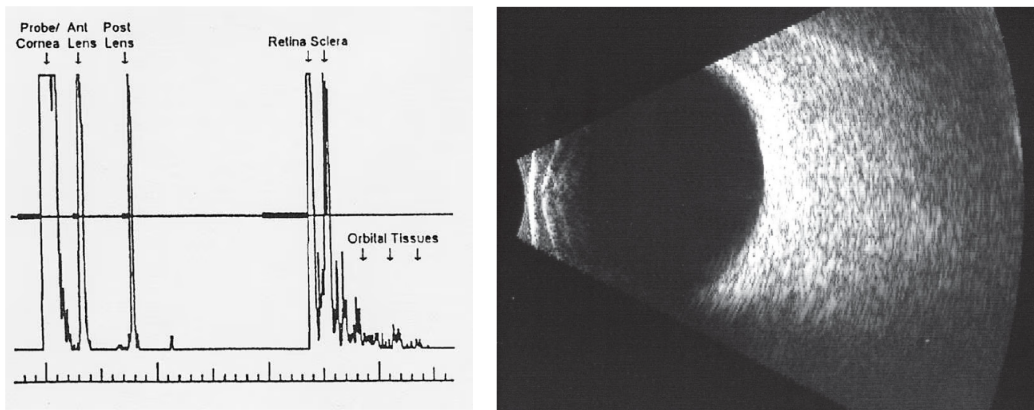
A-Scan (left) and B-Scan (right) Ultrasonography ⁵
